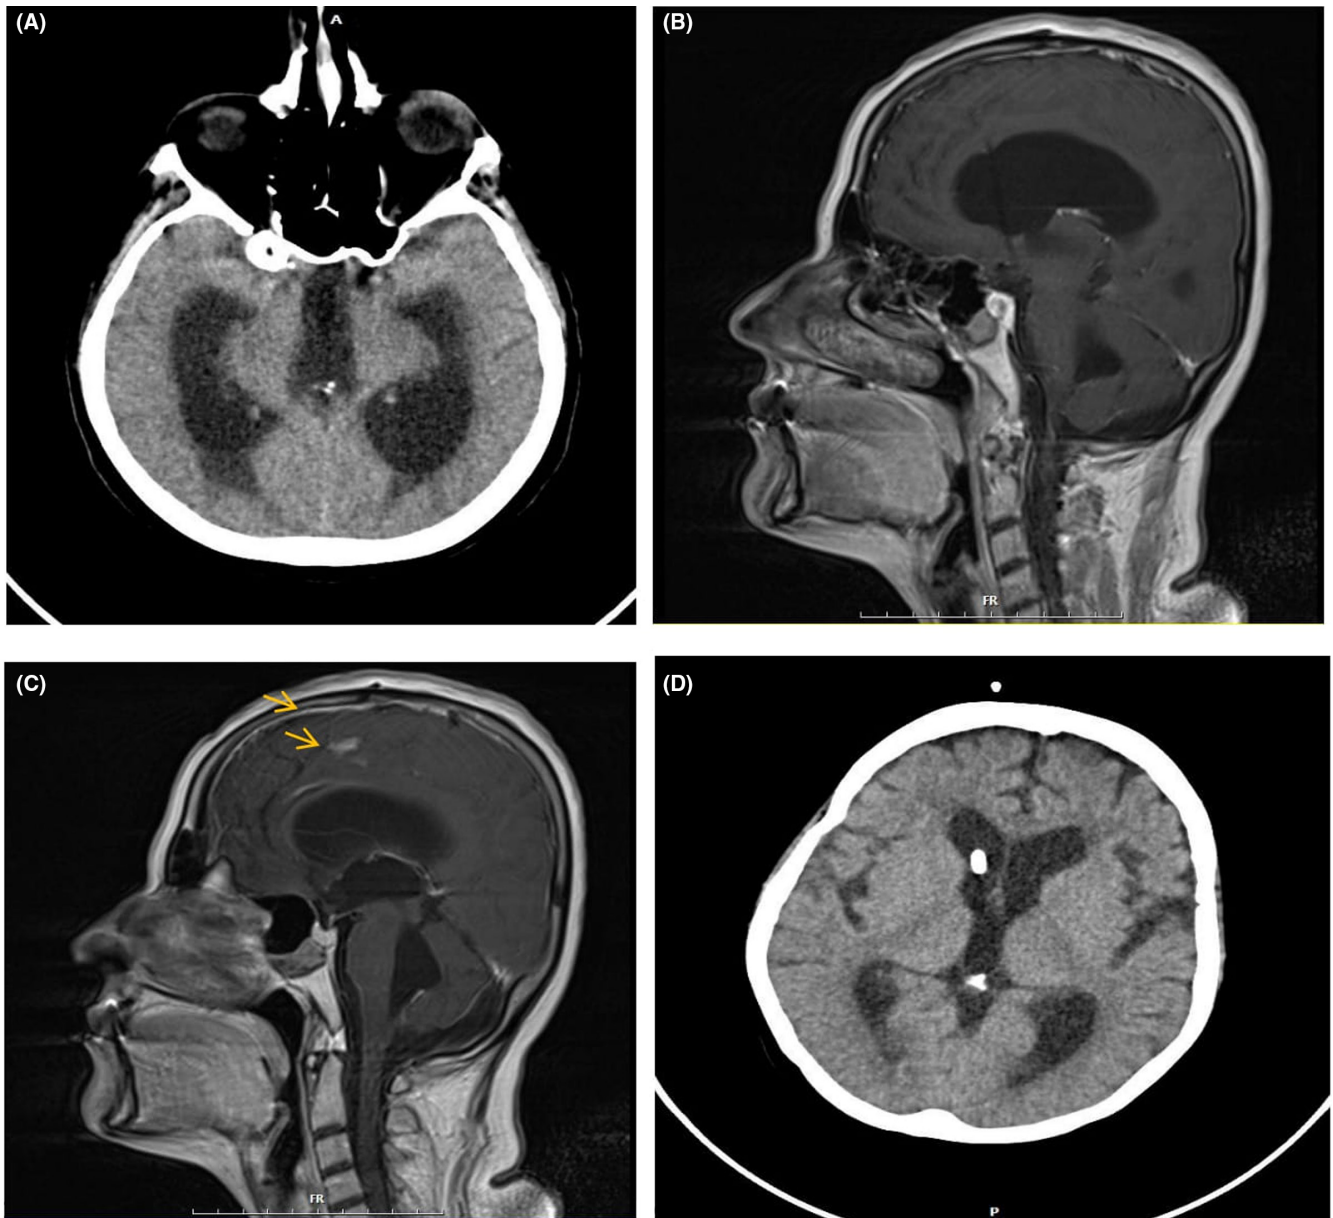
(A) Axial view Brain CT without contrast demonstrates severe hydrocephalus before extra ventricular drainage. (B, C) Sagittal view Brain MRI (T1) with gadolinium shows meningeal enhancement (Yellow arrow). (D) Axial Brain CT without contrast after extra ventricular drainage, that shows hydrocephalus was reduced.
